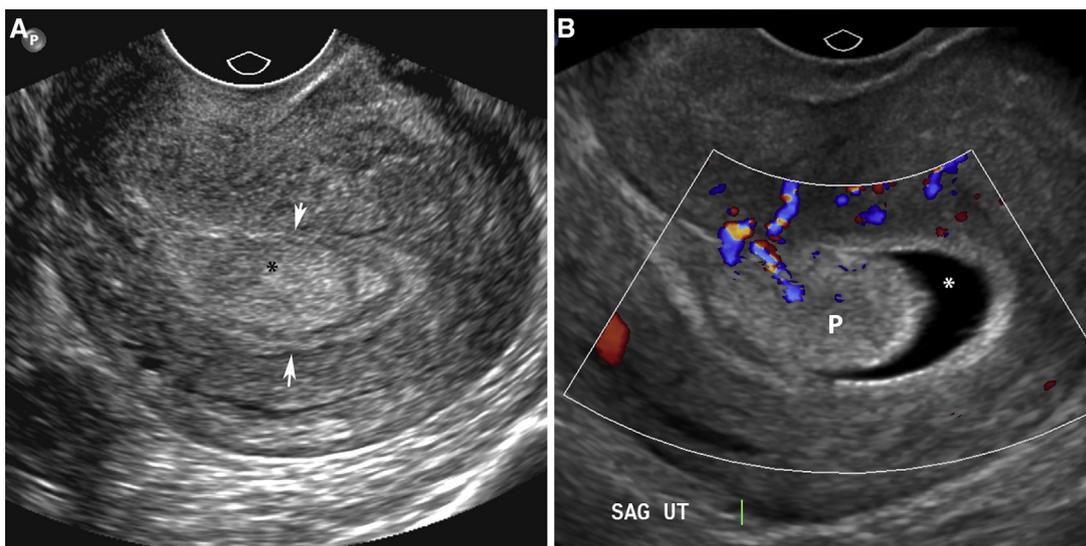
A 26-year-old premenopausal woman with pelvic pain. (A) Transvaginal sagittal ultrasound shows an echogenic mass in the endometrial cavity (asterisk). There is a hyperechoic rim around the echogenic mass that represents the normal endometrium known as the “hyperechoic line sign” (arrows). (B) Hysterosonogram was performed. Sterile saline distends the endometrial canal (asterisk). Fluid in the endometrial canal demonstrates the margins of the polyp (P) that measures  $1.2 \times 2.2 \times 3$  cm. Vascular stalk is shown with increased colour flow. Pulsed Doppler typically shows arterial flow in the vascular stalk (not shown). Patient had hysteroscopic polypectomy. Pathology revealed benign hyperplastic polyp without atypia. This figure is available in colour online at <http://carjonline.org/>.
